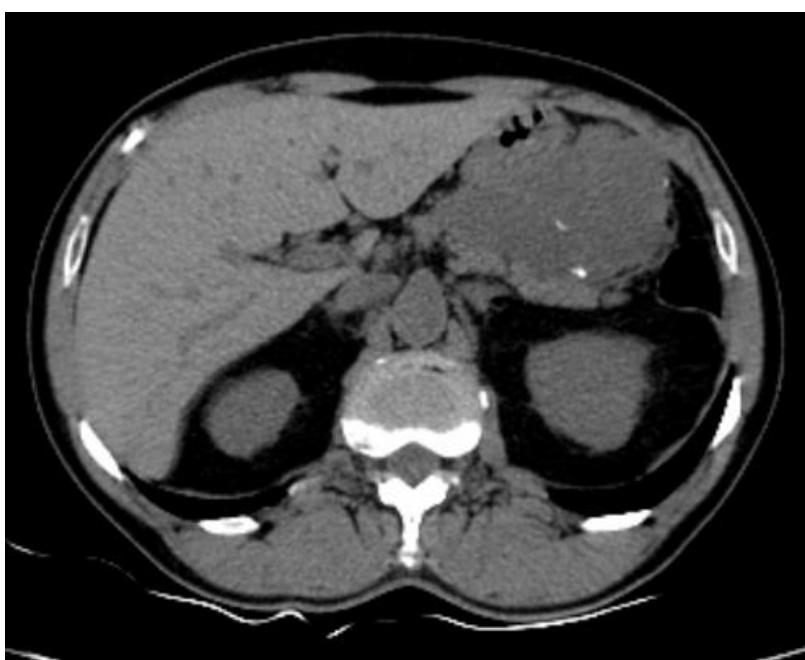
Abdominal CT scan showing the tumor infiltrating the body and tail of the pancreas.
